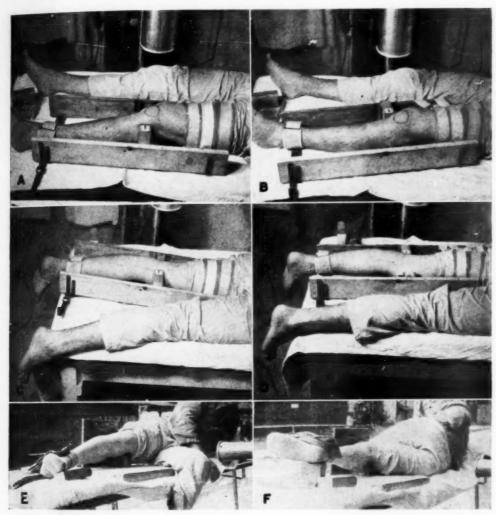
Further steps in technic. A. Spreading the medial side of the knee joint, anteroposterior view. B. and C. Spreading the lateral side of the knee joint, anteroposterior and postero-anterior views. D. Spreading the medial side of the knee joint, postero-anterior view. E and F. Spreading the lateral (E) and medial (F) sides of the knee joint over a fulcrum and employing a horizontal x-ray beam.
